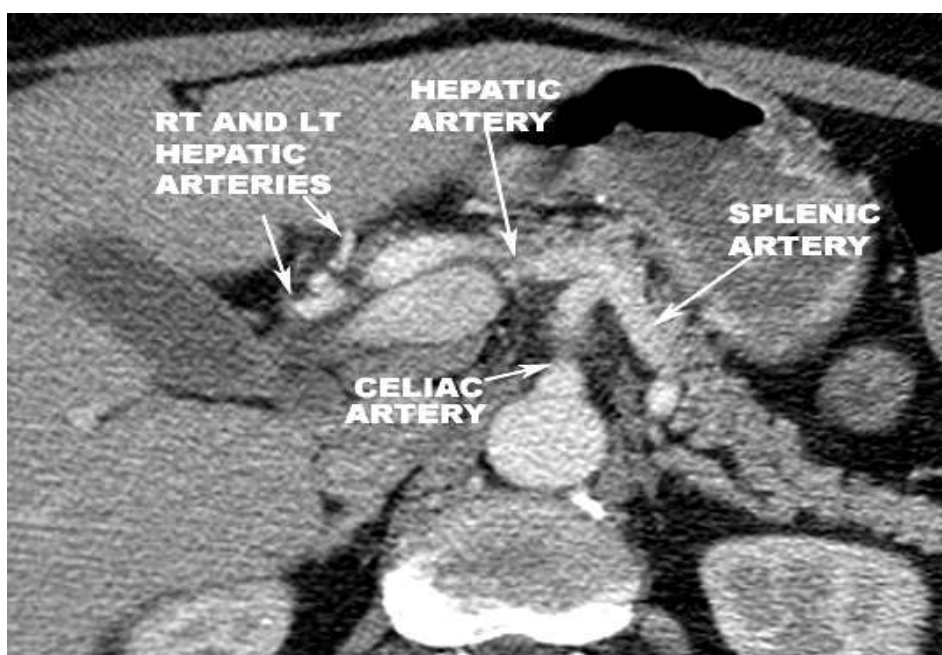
Shows a CT scan image of the celiac artery
